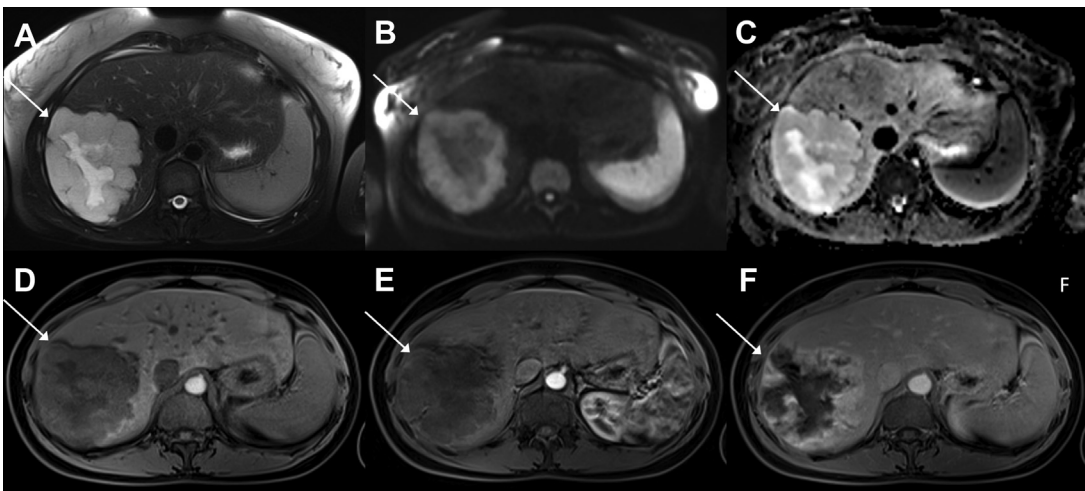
Giant hemangioma. Large liver lesion with heterogeneous hyperintensity on T2-weighted fat-saturated image (A), hyperintensity on diffusion (B) without restriction (C). The lesion was hypointense on T1-weighted fat-saturated image (D) with almost no enhancement in the arterial phase (E) and incomplete filling in the delayed phase (F).
